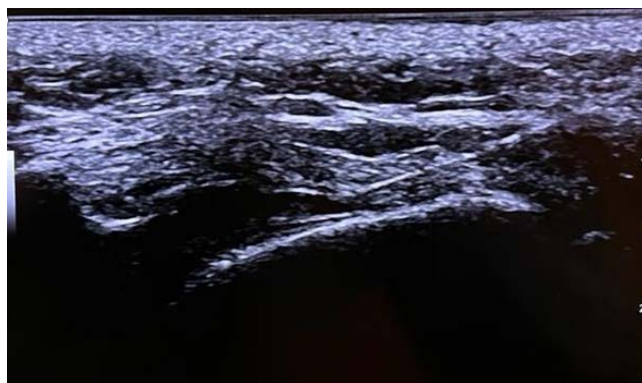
In-plane ultrasound-guided technique demonstrating the entry of the spinal needle into the caudal canal
